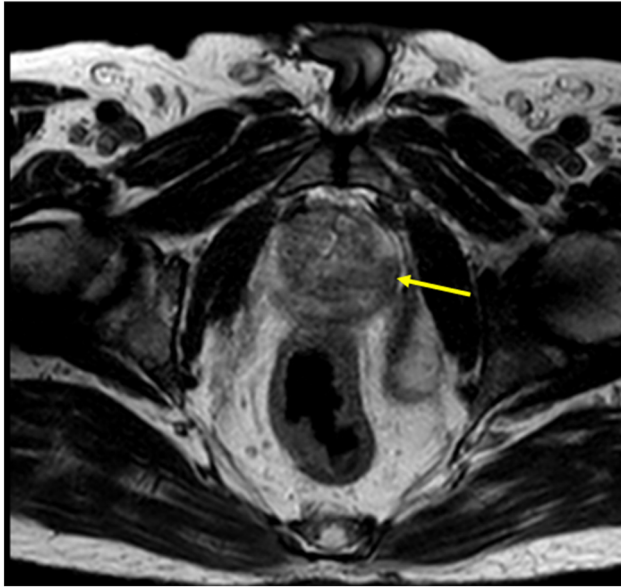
Prostate MRI demonstrated a convex contour of the prostate capsule lesion in T2-weighted (arrow).
